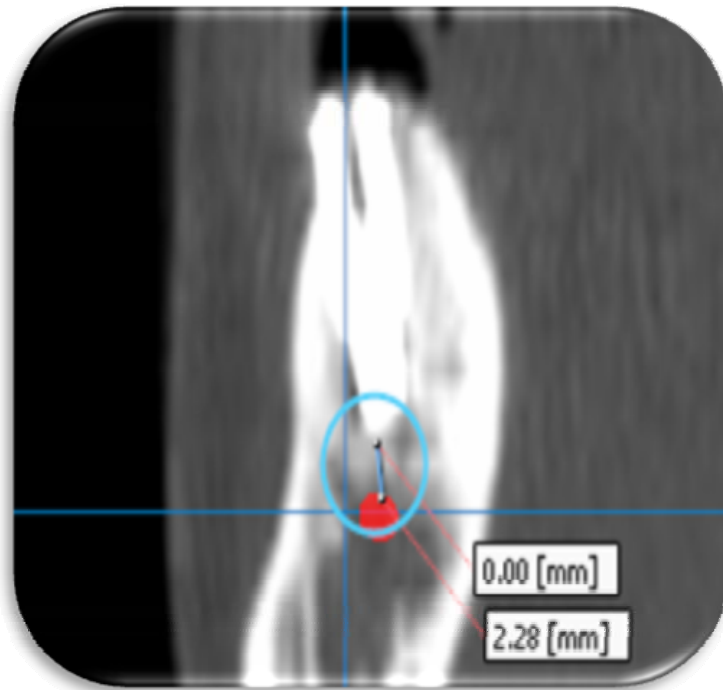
Measurement of D2. D2 was the distance from the implant apex to the anatomic structure in postsurgical CBCT.
